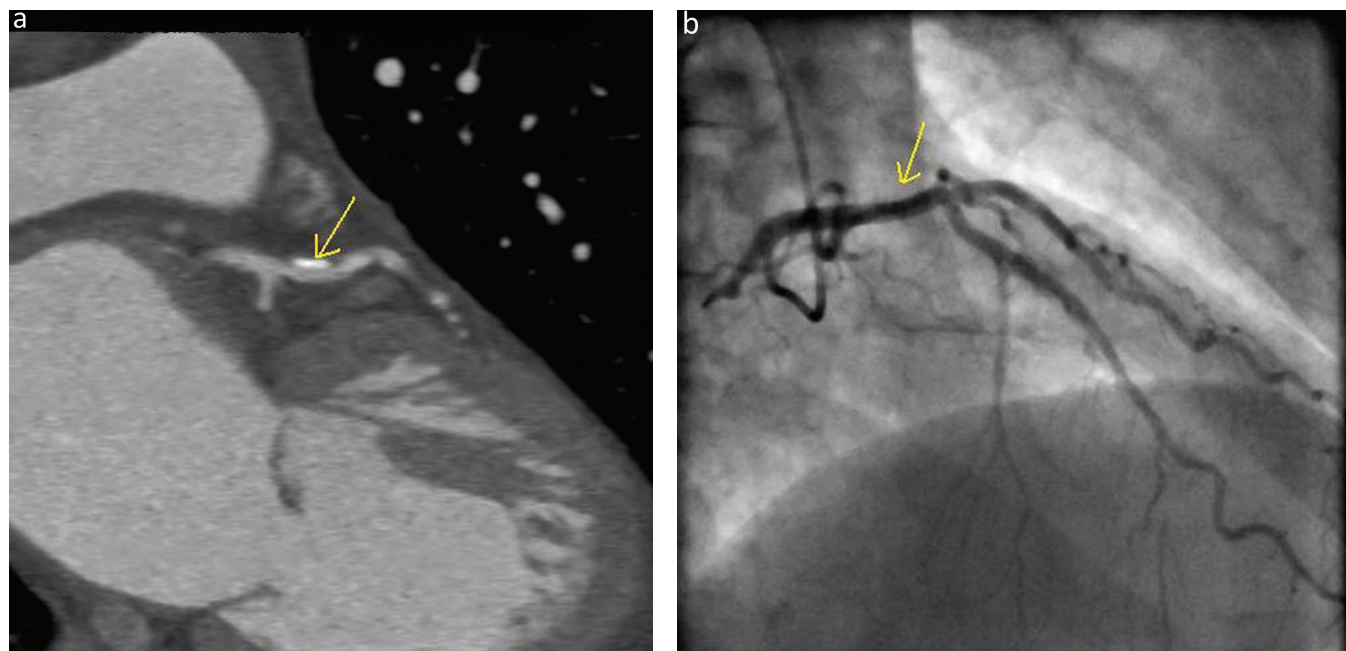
Left anterior descending artery atheroma. (a) CTCA of curved planar reformation showing mixed morphology plaque (arrow). (b) Catheter angiography showing mild irregularity but no significant stenosis (arrow). CTCA = computed tomographic coronary angiography.
